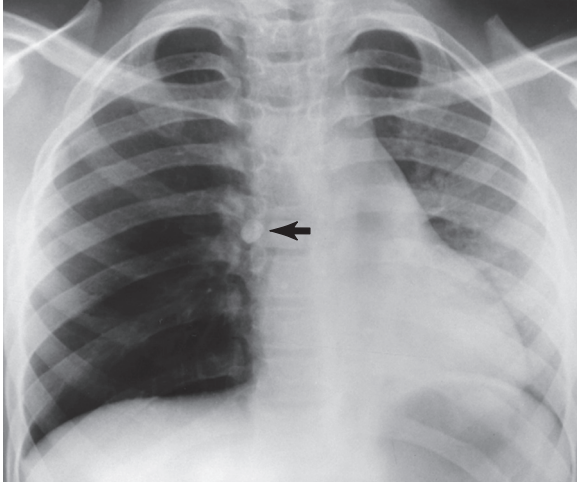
This expiratory frontal chest radiograph shows a normal decrease in left lung volume. A tooth (*arrow*) obstructs the right mainstem bronchus and causes air trapping in the right lung.
